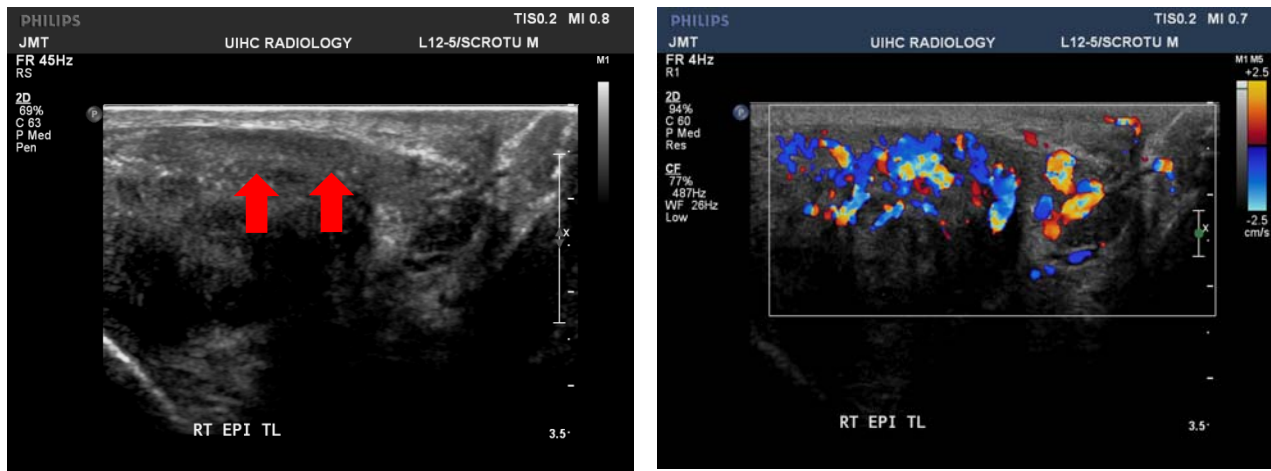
Grayscale and color Doppler of the right epididymis shows enlargement (red arrows) and hypervascularity.
